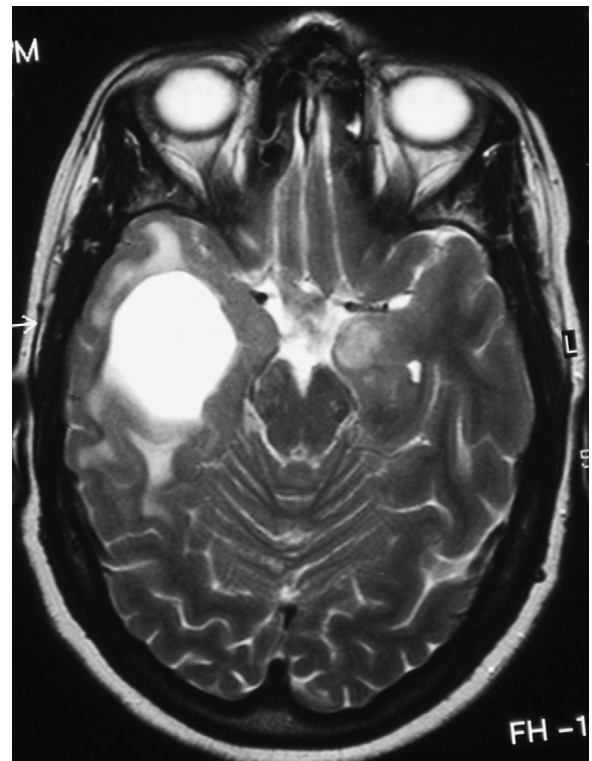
Axial MRI (T2 sequence). Peri-cystic hyperintensity corresponding to transependymal resorption. Note the brainstem and left hippocampus signal anomalies. Right temporal herniation.
